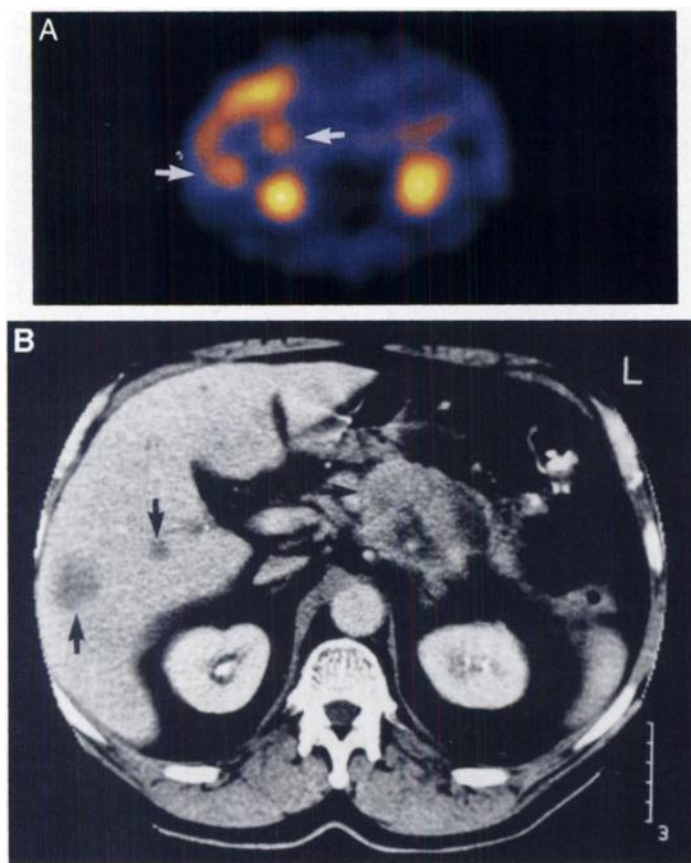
Iodine-123-VIP receptor image of liver metastases from pancreatic cancer. (A) Liver metastases (arrows) indicated by focal tracer accumulation, while the primary cancer (7 cm in diameter) was not detected by ^{123}I -VIP. (B) Corresponding CT image of liver lesions (arrows) also depicting the large pancreatic tumor.
